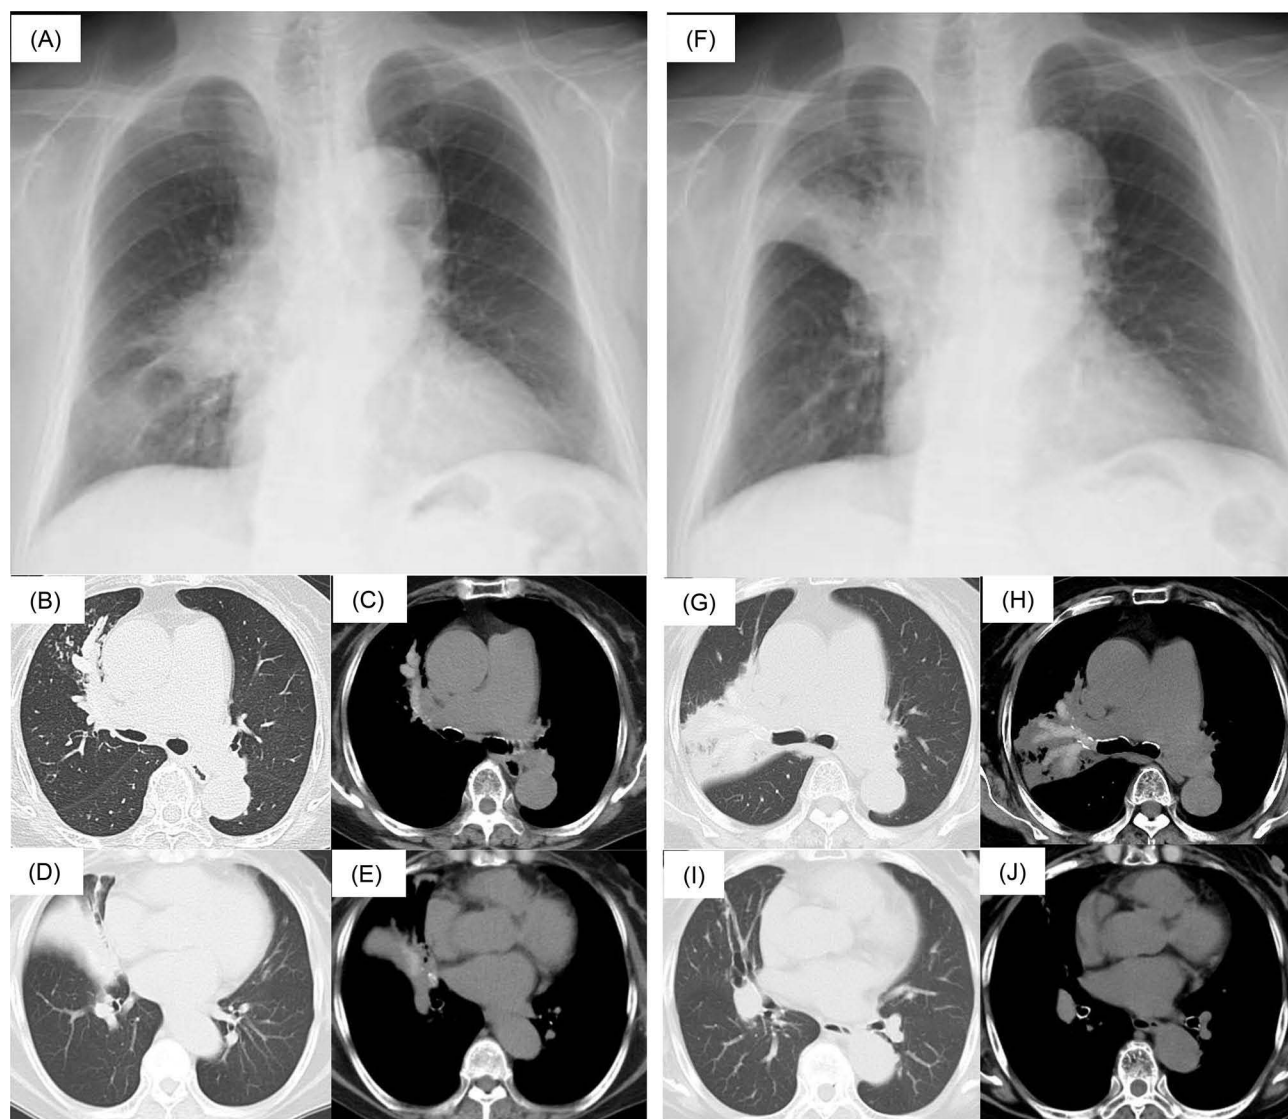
Findings on chest X-ray and computed tomography (CT) before (A–E) and after treatment with mepolizumab (F–J). (A) Before treatment, the chest X-ray shows decreased density in the middle central and lower peripheral fields of the right lung. (B–E) Chest CT shows a funicular shadow in the right upper lobe and consolidation in the right middle lobe on the lung window setting with high attenuation structures on the mediastinal window setting in the B3 and B4 bronchi. (F) After treatment with mepolizumab, the chest X-ray shows decreased density in the upper field with disappearance of the decreased density in the middle central and lower peripheral field of the right lung. (G–J) Chest CT shows consolidation in the right upper lobe on the lung window setting, with high attenuation structures on the mediastinal window setting in the B2 and B3 bronchi, even though those in the B4 bronchus have recovered with resolution of obstructive atelectasis of the right middle lobe.
